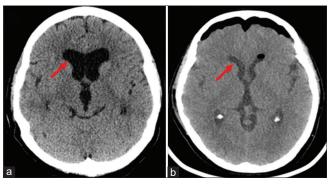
(a) Preoperative axial computed tomography (CT) demonstrating ventriculomegaly. (b) Postoperative Axial CT demonstrating decrease in ventricle size following endoscopic third ventriculostomy. Pneumocephalus is evident on scan.
